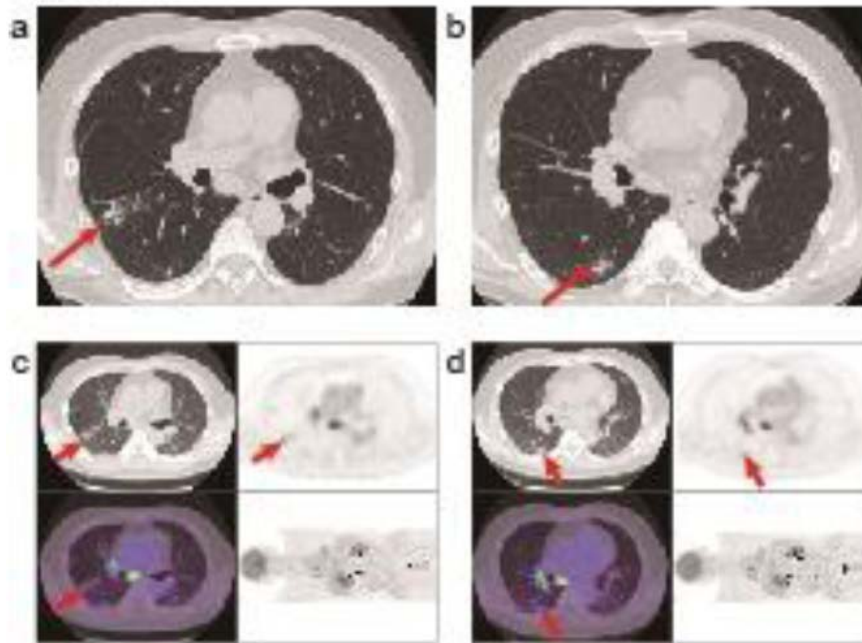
Findings on Imaging of lesions in lung, diagnosed as lung NET in patient # 2. (a) Lung lesions near right horizontal fissure spot, (strip and flake like in shape); with slightly increased metabolism (SUVmax 1.9) (c). (b) Lung lesion in right lower lung; with slightly increased metabolism (d).
